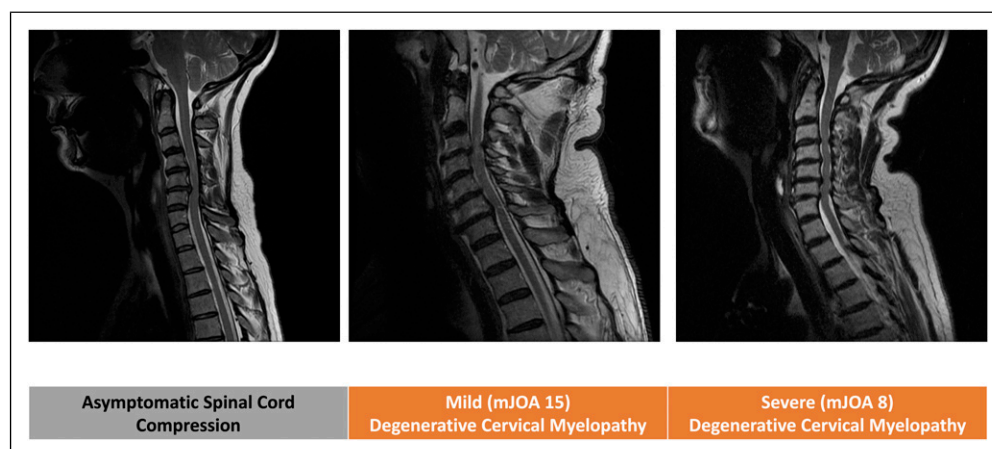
Cord compression does not represent DCM. Series of T2 weight sagittal cervical spine MRI. Cord compression is commonly incidental [A], even with hyperintensity signal change, and the amount of compression weakly correlates to the disease severity (A vs B vs C).
